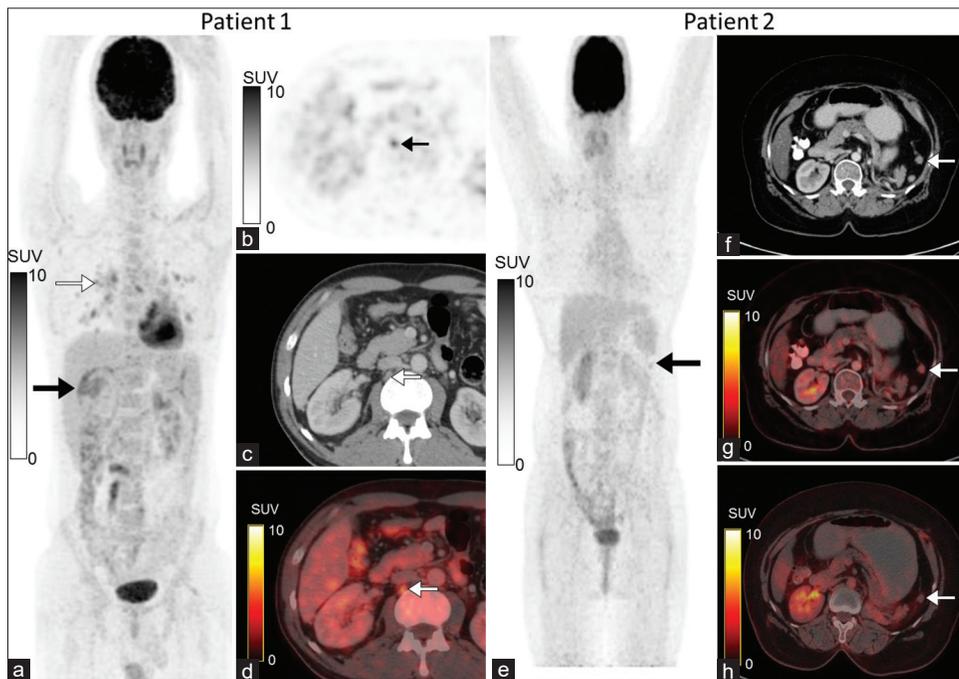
Patient 1 (a-d): A 37-year-old male, a diagnosed case of adrenocortical carcinoma, underwent fluoro-2-deoxyglucose-positron emission tomography-computed tomography for staging. Maximum intensity projection image (a) showed fluoro-2-deoxyglucose avidity in the primary lesion in the right adrenal gland (black arrow) and multiple foci of fluoro-2-deoxyglucose avidity in the lung region (white arrow) which was secondary to infective infiltrates in the lung. Transaxial positron emission tomography (b) was showing a focus of increased fluoro-2-deoxyglucose avidity (black arrow) which localized to a subcentimetric retrocaval lymph node which was negative for metastasis in the computed tomography component (c) but the fused positron emission tomography-computed tomography (d) images showed focal fluoro-2-deoxyglucose avidity in the lymph node which altered the management to include adjuvant radiotherapy. Patient 2 (e-h): A 50-year-old female underwent fluoro-2-deoxyglucose-positron emission tomography-computed tomography for restaging (e) following surgical resection of left adrenal adrenocortical carcinoma, which showed a faintly fluoro-2-deoxyglucose avid lesion (black arrow) in the left infrapleural region which was suspicious for metastatic deposit on computed tomography (f) but negative according to fluoro-2-deoxyglucose-positron emission tomography-computed tomography (g). The fluoro-2-deoxyglucose-positron emission tomography-computed tomography done for surveillance after 2 years (h) showed no change in the lesion confirming its benign nature. Fluoro-2-deoxyglucose-positron emission tomography-computed tomography helped in changing the management from local radiotherapy to observation alone
